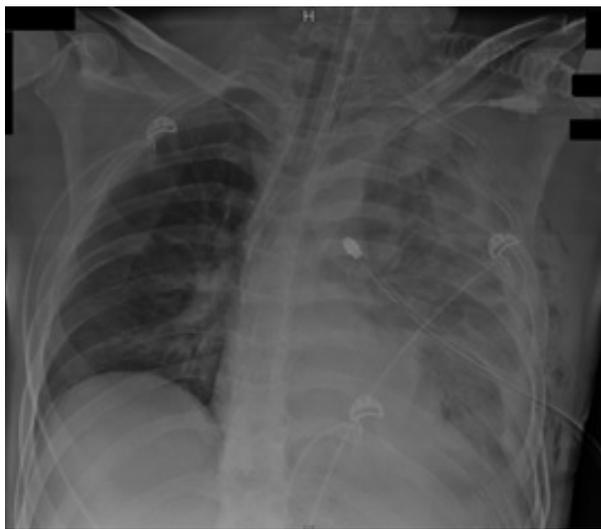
Post-operative day 1 after diaphragm reparation, chest X-ray shows the fluid collection occupying the left pleural cavity and collapsing the lung
